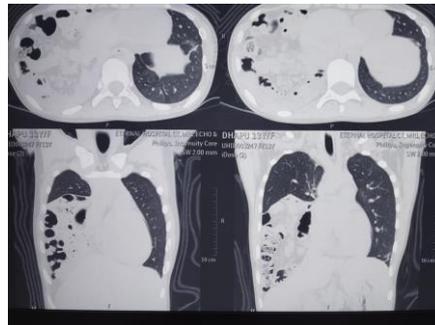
CT scan showing Bochdalek Hernia with Chilaiditi's Sign
